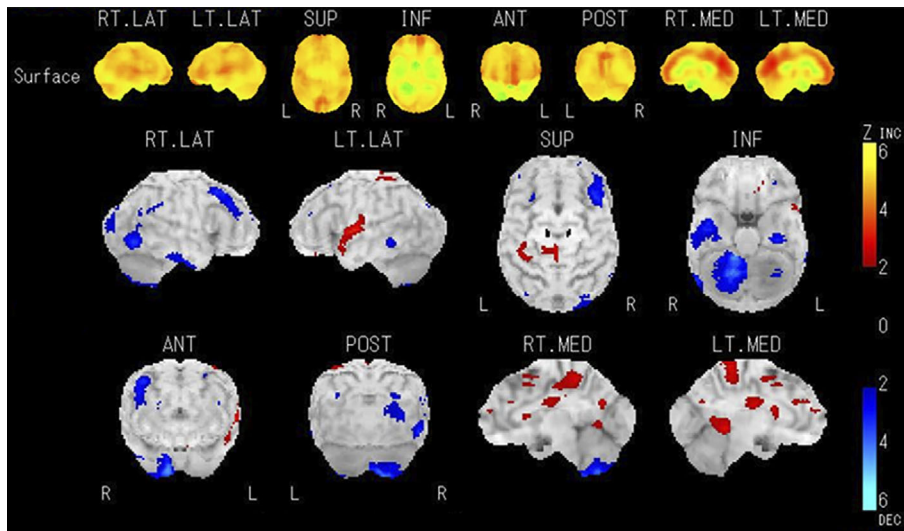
Results of N-isopropyl-p- ^{123}I iodoamphetamine (^{123}I -IMP) SPECT. No specific decrease in cerebral blood flow was observed in the 3D stereotactic surface projection analysis. SPECT: single photon emission computed tomography
